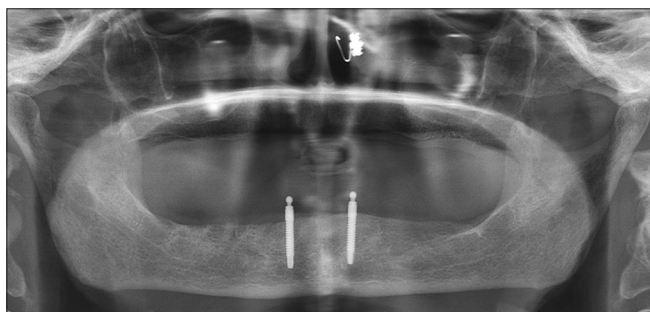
Postoperative orthopantomogram showing two implants in B and D location
